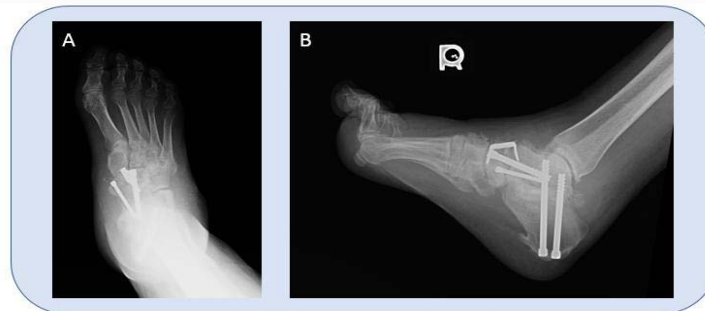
AP (A) and lateral (B) foot X-rays taken 2 weeks Post-Operative. Osseous sequelae dorsally at the midfoot remaining from the surgery.
